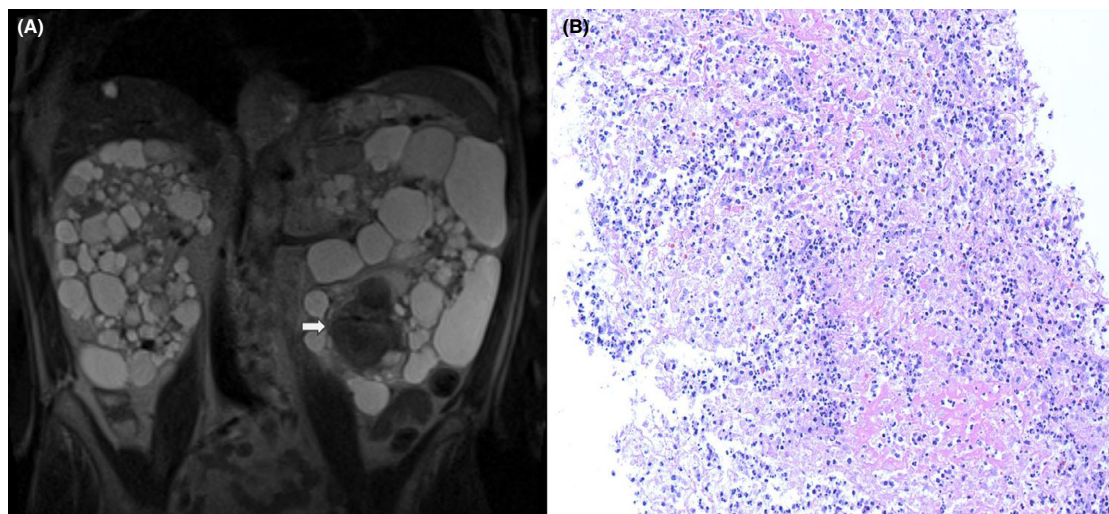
(A) Magnetic resonance imaging of renal mass with no intravenous contrast, demonstrating approximately 5.7 cm × 5.8 cm × 6.6 cm renal mass in lower pole of the left kidney with peripheral nodularity and intermediate T2 signal intensity (arrow) concerning for renal cell carcinoma. (B) Biopsy of the lesion demonstrating necrotic tissue and fragments of inflamed kidney parenchyma with areas of fibrin deposition and no definitive evidence of carcinoma.
